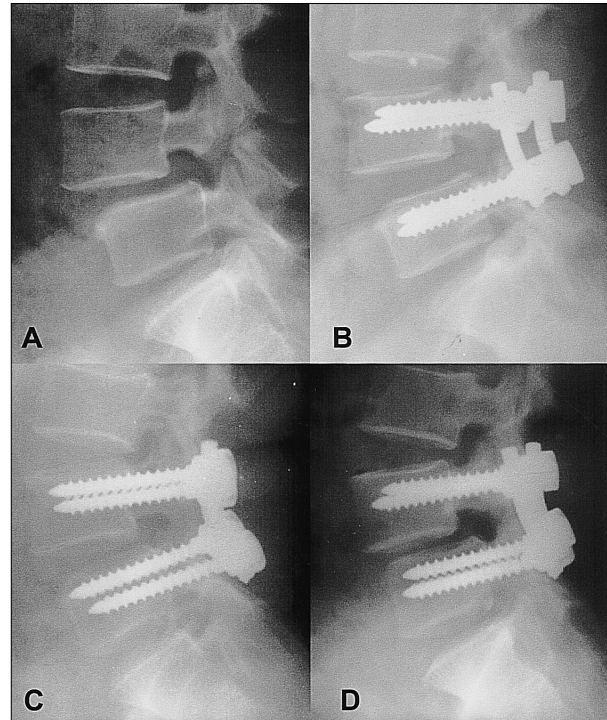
A. Preoperative lateral radiography of a 40-year-old woman with spondylolytic spondylolisthesis shows anterior slip of L4 and narrowing of the L4-5 disc space. B. Postoperative lateral radiography of a 40-year-old woman treated by posterolateral fusion with pedicle screws shows good reduction and the restoration of disc space. C. Postoperative 6-month follow-up lateral radiography of the lumbar spine shows loss of reduction, narrowing of disc space, and breakage of the left L5 pedicle screw. D. Postoperative 35-month follow-up lateral radiography of the lumbar spine shows further loss of reduction, narrowing of disc space, and kyphotic deformity of L4-5.
